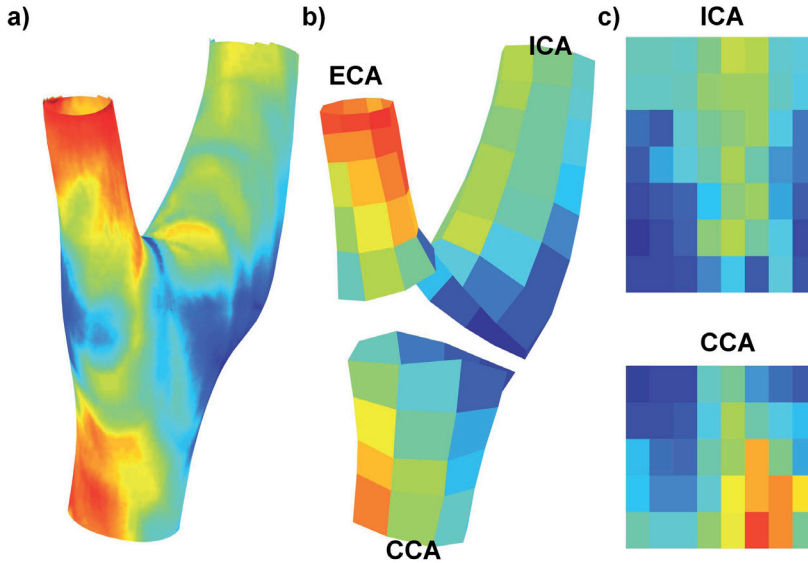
a) An example of WSS distribution based on PC MRI b) The carotid bifurcation was divided into three parts: CCA, ECA and ICA. These parts were partitioned into patches by 8 circular segments (45°) and 2 mm longitudinal segments resulting in approximately 120 patches per artery. c) These patches were flattened. CCA and ICA data were analyzed. ECA was excluded from the analysis.
